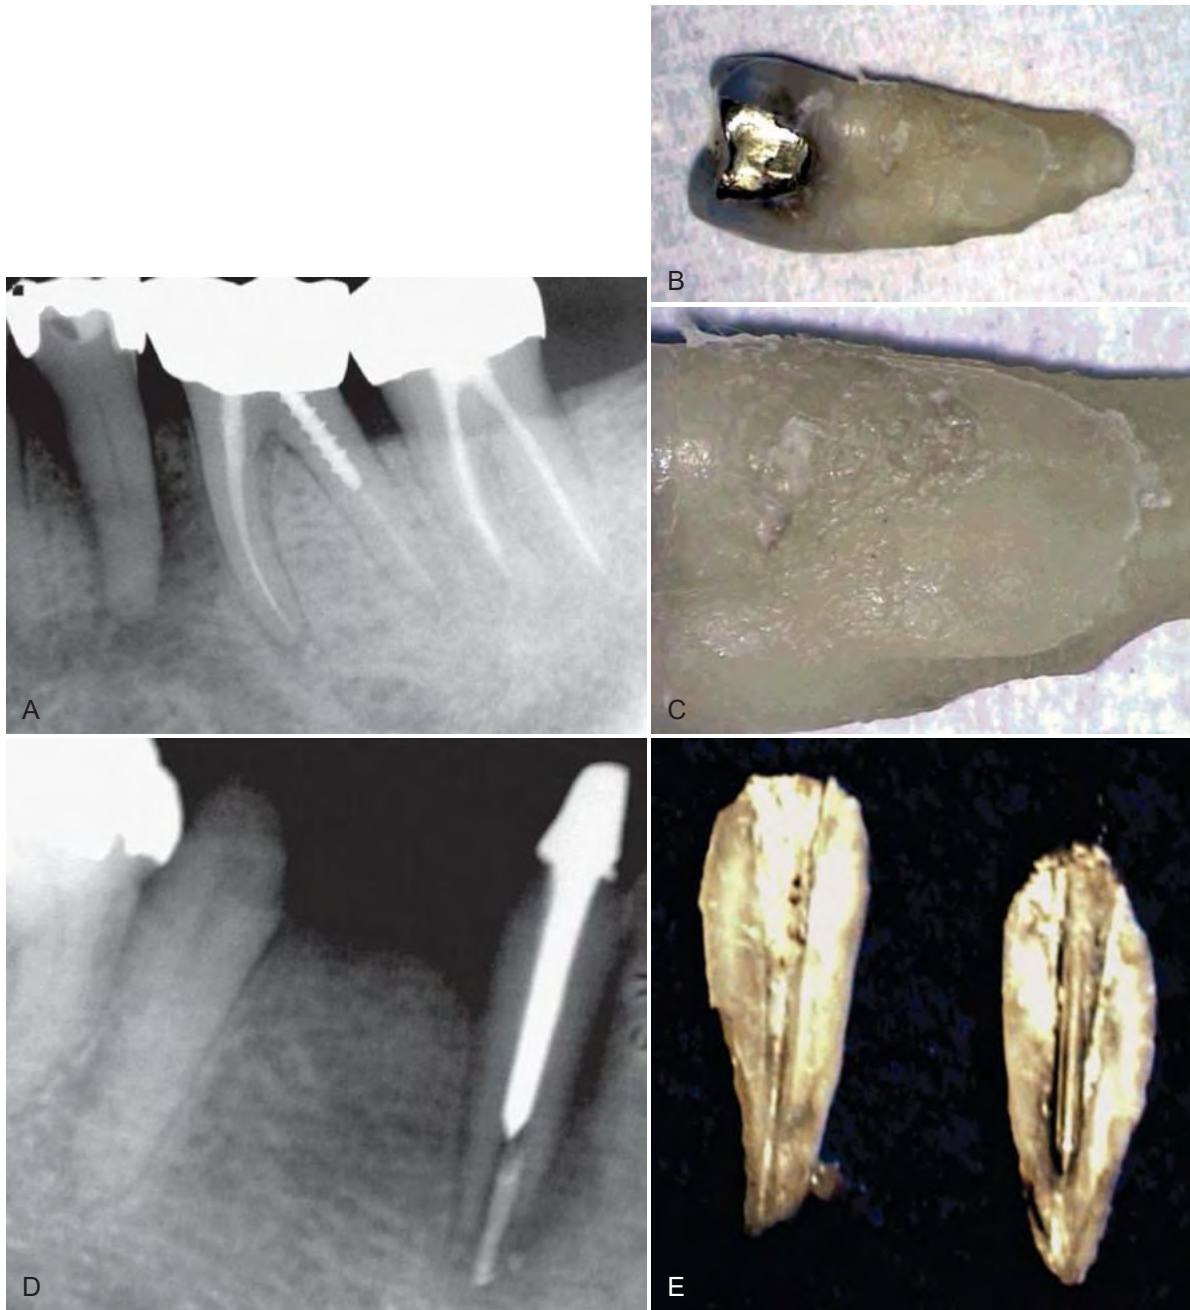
Poorly fitting intracoronaral restorations can place stresses within the tooth that can cause a vertical root fracture. A, This radiograph of a mandibular second premolar (with a gold inlay) reveals extensive periapical and periradicular bone loss, especially on the distal aspect. B, The tooth pulp tested nonvital, and there was an associated 12-mm-deep, narrow, isolated periodontal pocket on the buccal aspect of the tooth. After the tooth was extracted, the distal aspect was examined. C, On magnification ($\times 16$) the distal aspect of the root revealed an oblique vertical root fracture. Similarly, the placement of an ill-fitting post may exert intraradicular stresses on a root that can cause a fracture to occur vertically. D, This radiograph depicts a symmetrical space between the obturation and the canal wall, suggesting a vertical root fracture. E, After the tooth is extracted, the root fracture can be easily observed.
